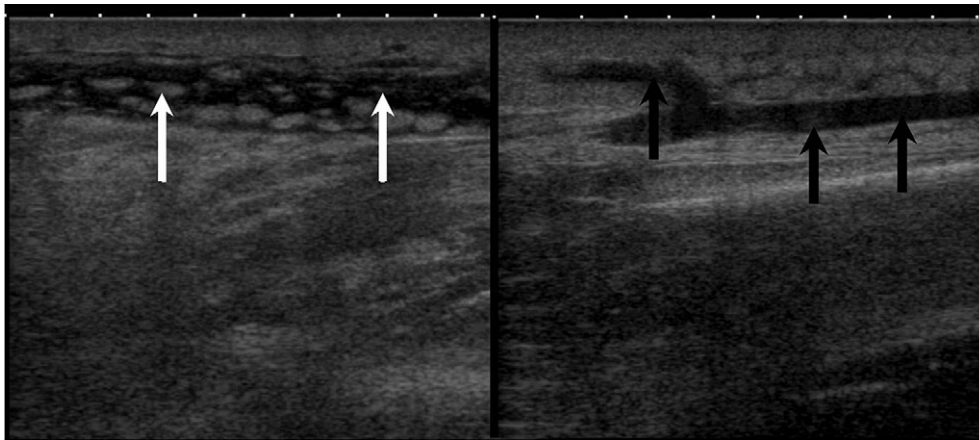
High-frequency ultrasound image using a linear probe shows cellulitis of the abdominal wall. Note the oedema (white arrows) and the dilated superficial vein (black arrows).
